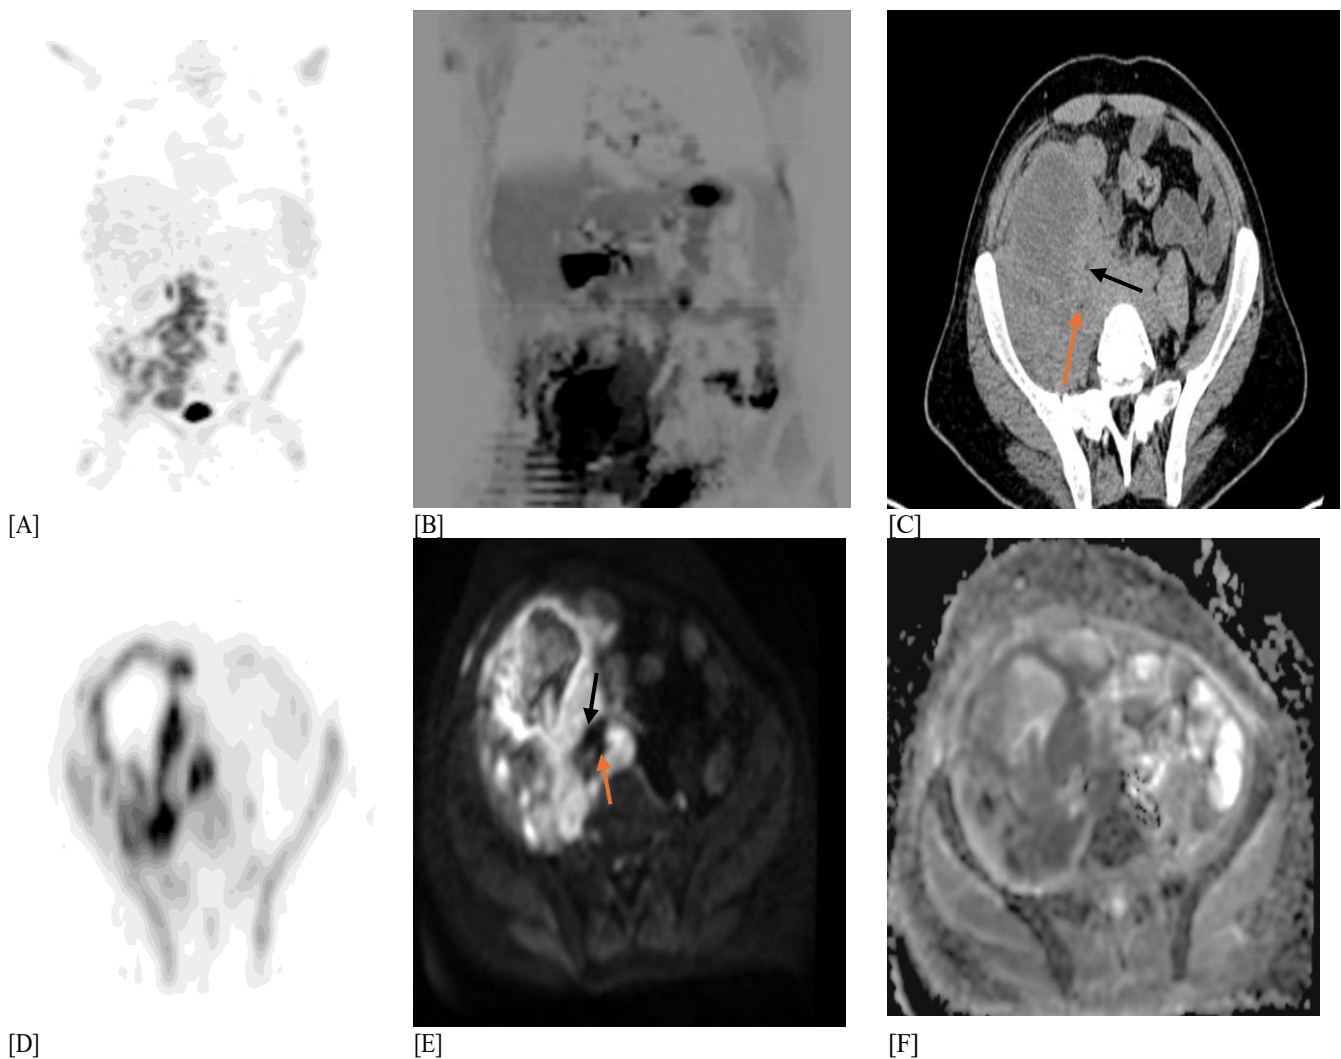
Stage V HL male patient showing intense FDG uptake and restricted diffusion corresponding to a sizable right lower abdominal heterogeneous mass lesion is seen inseparable from the right psoas and iliocostalis muscles. Metabolic activity [and diffusion restriction] of multiple abdomino-pelvic lymphadenopathy. [A] Coronal PET CT image. [B] Coronal MPR DWI b800 image in the inverted grey scale. [C] Axial non-contrast CT image shows the previously described mass lesion encasing the external iliac artery [black arrow] with indistinct borders; the internal iliac artery is not completely identified [orange arrow]. [D] The peripheral portion of the right iliac fossa mass lesion shows peripheral increased metabolic activity, with an SUVmax of about 25, with central FDG-starving areas of necrosis. [E] Axial b800 DWI MRI image shows the previously described mass lesion complete encasement of both external and internal iliac arteries with no gross invasion [arrows], which appeared as signal void, so it was better than NC PET CT images in vascular relation assessment and characterization without the need for contrast injection. [F] ADC axial image, the peripheral portion of the lesion is low signal on ADC, value of ADC max 0.99, min 0.67, mean 0.81 $\times 10^{-3}$ mm²/s.
